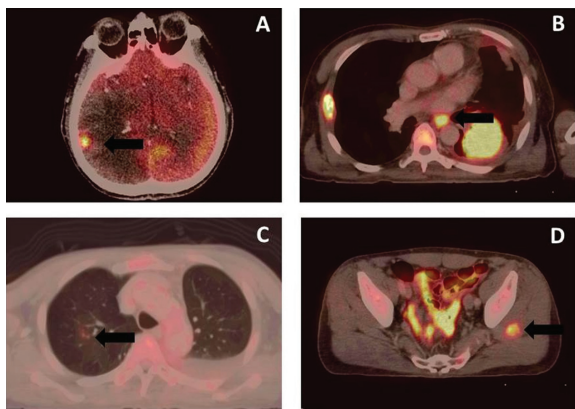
Upstaged FDG PET/CT. A 61-year-old man with metastatic NSCLC. A-D: FDG PET/CT showed unexpected brain, mediastinal node, intrapulmonary and gluteus muscle metastases.
